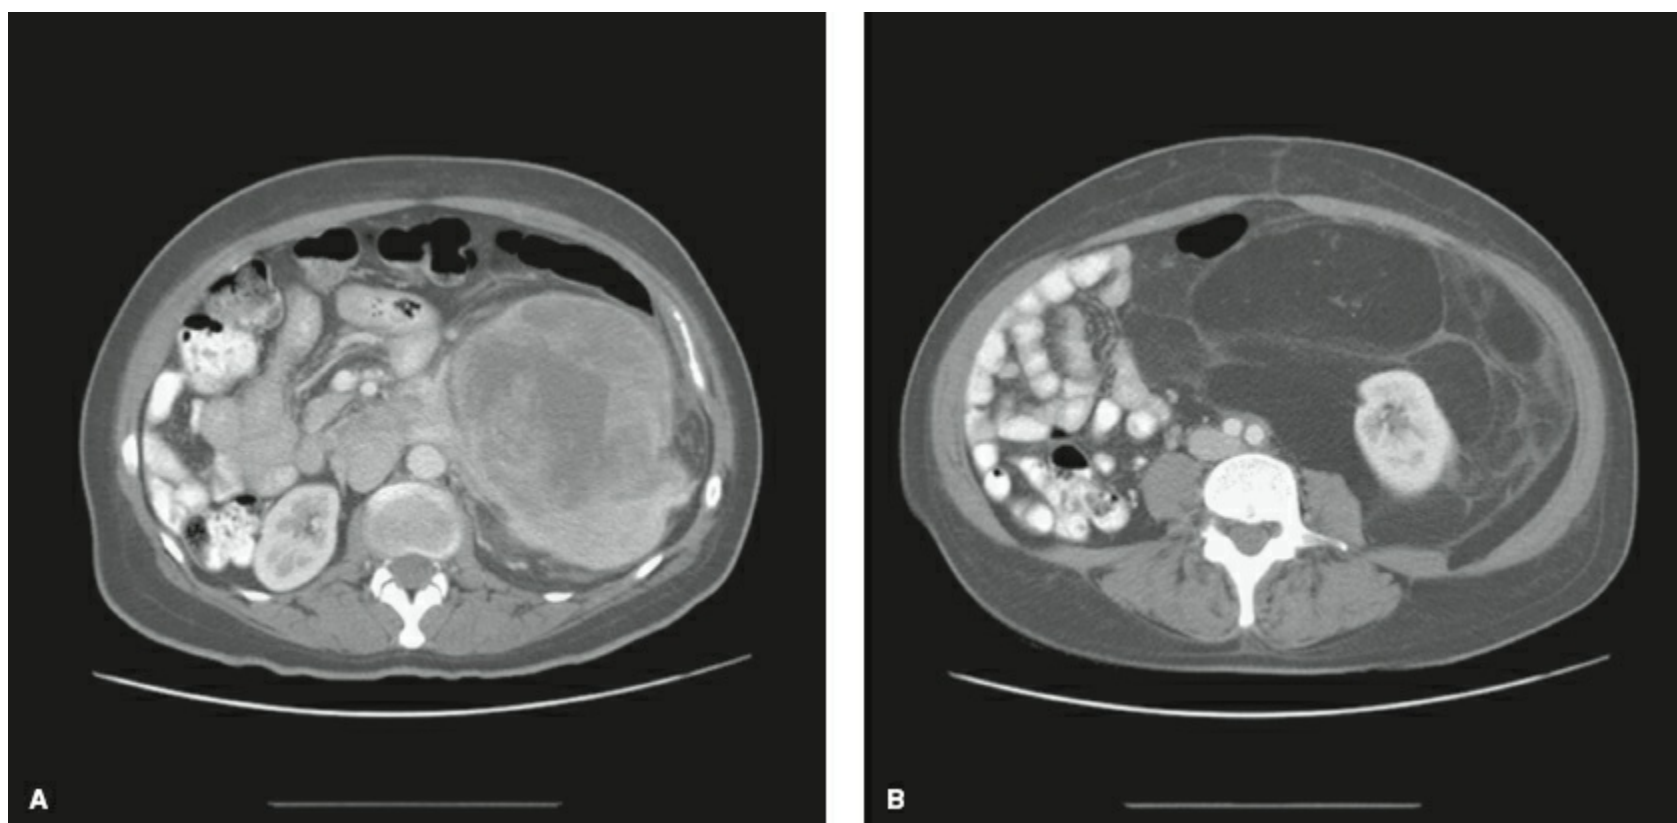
Dedifferentiated liposarcoma of the retroperitoneum. This 51-year-old woman presented with only vague symptoms of abdominal fullness from a very large retroperitoneal mass. The CT scan demonstrates a heterogeneous soft tissue mass in the upper abdomen (A), which blends into a more fatty component (B) which encases the left kidney and displaces abdominal contents. She underwent radical resection en bloc left nephrectomy, distal pancreatectomy, splenectomy, left colectomy, and segmental resection of inferior vena cava.
